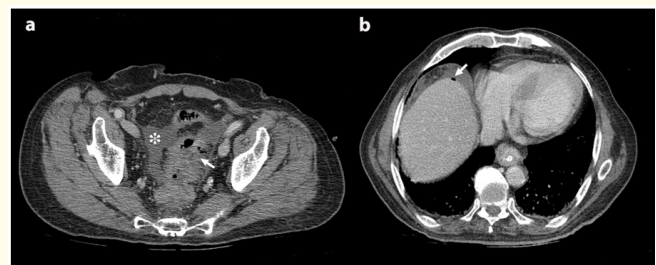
Axial contrast enhanced CT scan of the abdomen and pelvis shows discontinuation in the left side of rectal wall with adjacent extraluminal gas (arrow in panel a). There is also free fluid in the pelvis (asterisk in panel a). Free fluid and a small focus of intraperitoneal air (arrow in panel b) are also seen on the anterior surface of the liver (b).
